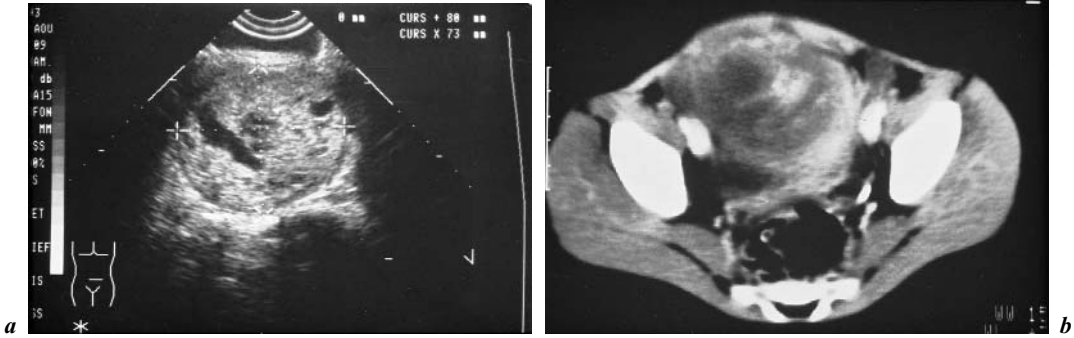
Fibrosarcoma. a Ultrasonography. Heterogeneous ovarian mass with a predominant tissue component. b CT scan. Solid tumor with no fat or calcifications, and heterogeneous uptake of contrast agent.
